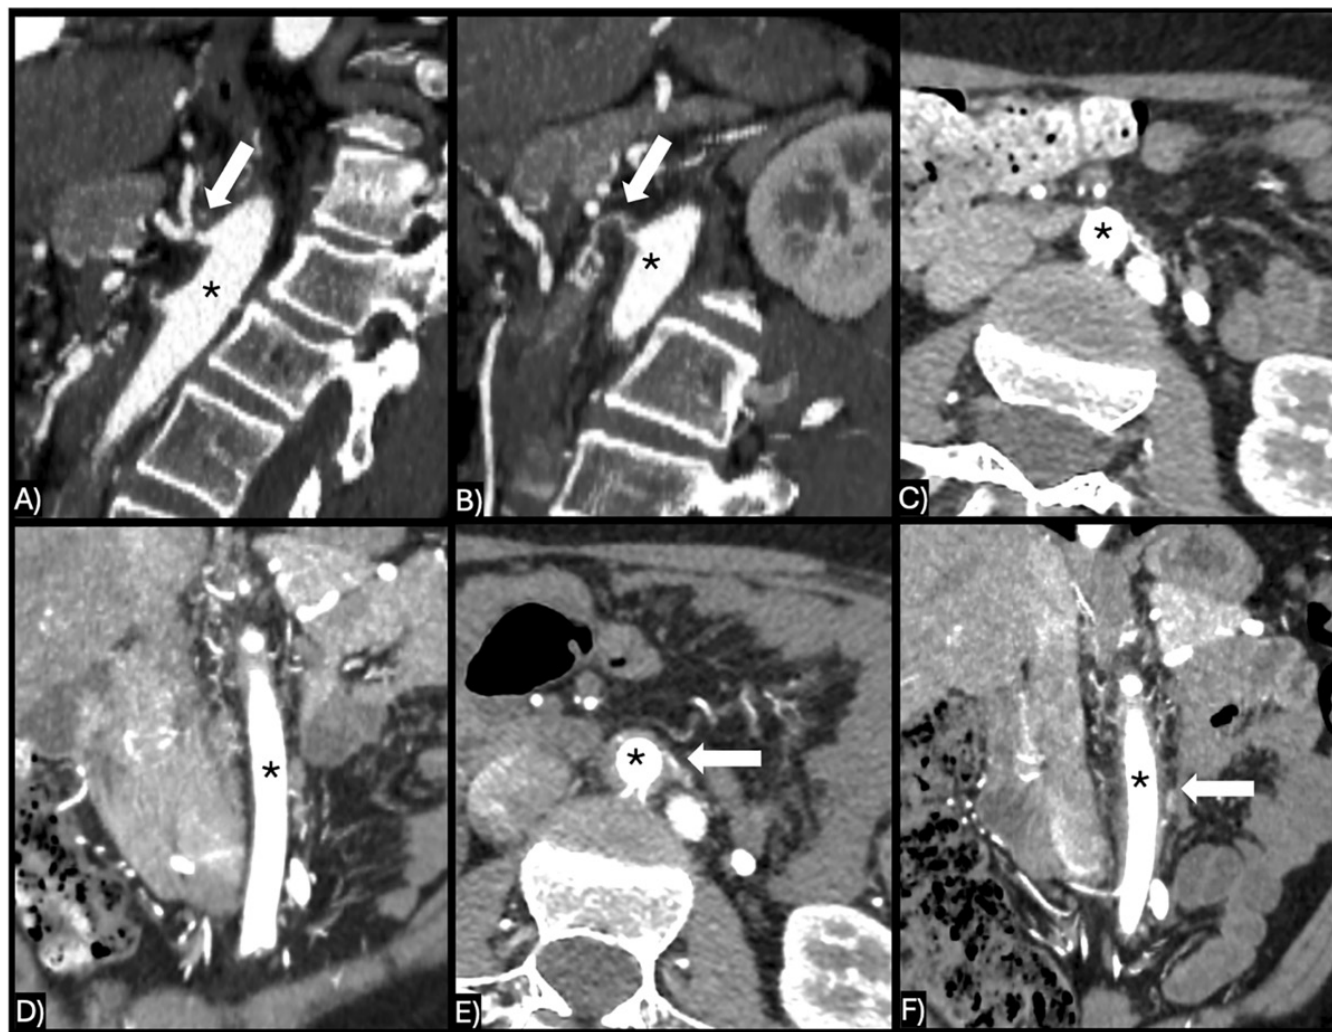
Sagittal oblique reconstructed CT angiography images in February 2024 reveal stenoses in (A) superior mesenteric arteries (arrow) and (B) celiac (arrow) just distal to their origin from the aorta (asterisk). Axial (C) and coronal-oblique reformatted (D) CT angiography images show no wall thickening of the abdominal aorta (asterisk). Despite sustained clinical and biochemical control of ulcerative colitis at one-year follow-up in February 2025, axial (E) and coronal-oblique reformatted (F) CT angiography images demonstrate progressive, diffuse wall thickening (white arrow) of the abdominal aorta (asterisk).
